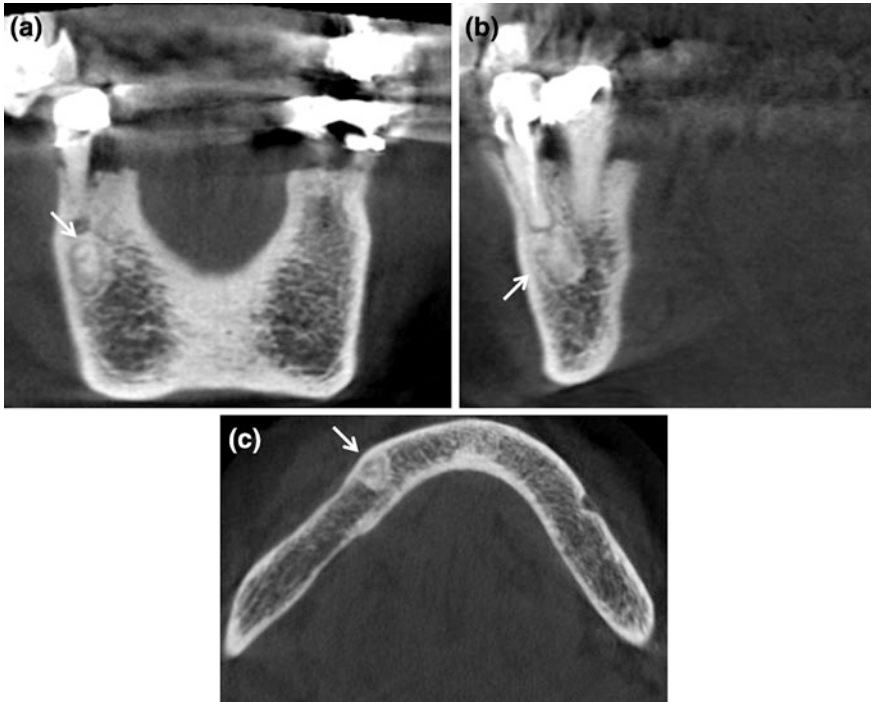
CBCT coronal (a), sagittal (b) and axial (c) sections showing central high-density mass attached to the apex of 44 surrounded by a well-defined low-density area (*thin arrow*). The radiographic signs suggest a benign tumor like a benign cementoblastoma
